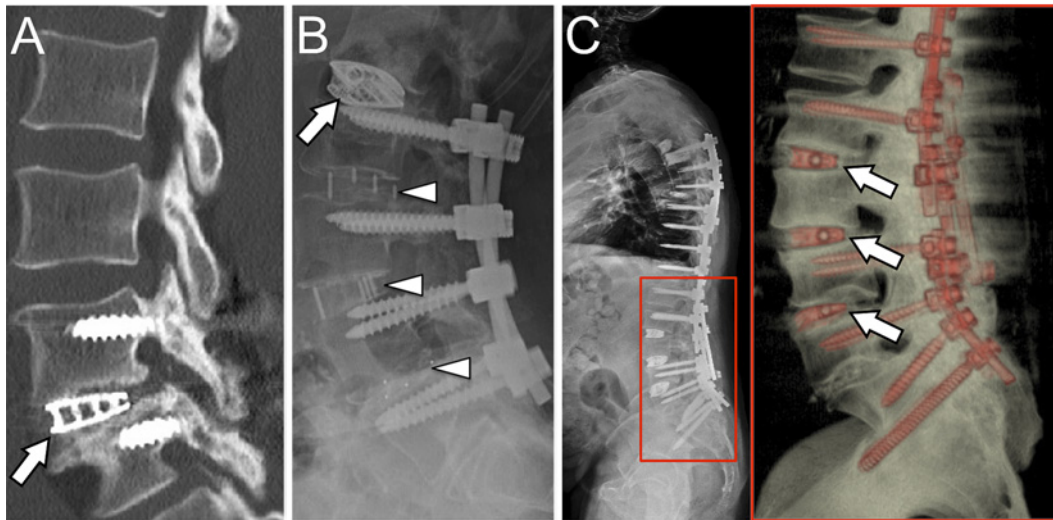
(A) Representative close-up view of a lateral postoperative computed tomography showing a single-level titanium cage at L4/5 (arrow) with supplemental posterior spinal instrumentation. (B) Representative lateral postoperative radiograph showing a stand-alone single-level titanium cage at L1/2 (arrow) for adjacent segment failure in a patient with prior placement of L2 to L5 interbody polyetheretherketone cages (arrow heads) and supplemental posterior spinal instrumentation from L2 to L5. (C) Lateral scoliosis radiograph and close-up view of 3D reconstruction of thoracolumbar hardware following computed tomography, depicting implementation of laterally placed titanium cages at L2/3, L3/4, and L4/5 (arrows) in a long-segment thoracolumbar construct for degenerative scoliosis.
